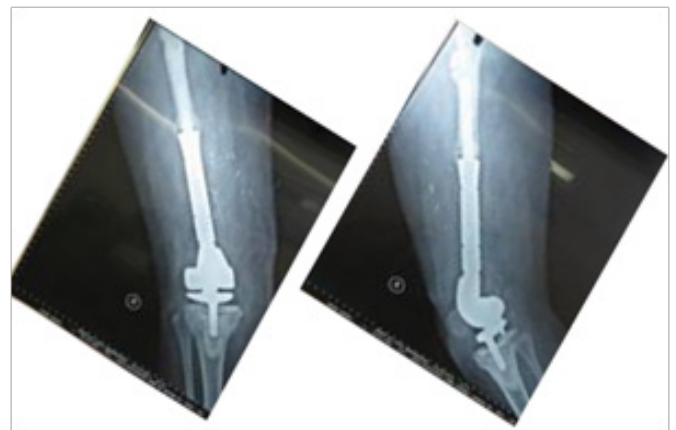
Post-operative radiograph showed that the prosthesis was held in position. Sign of inflammation was no longer seen.
